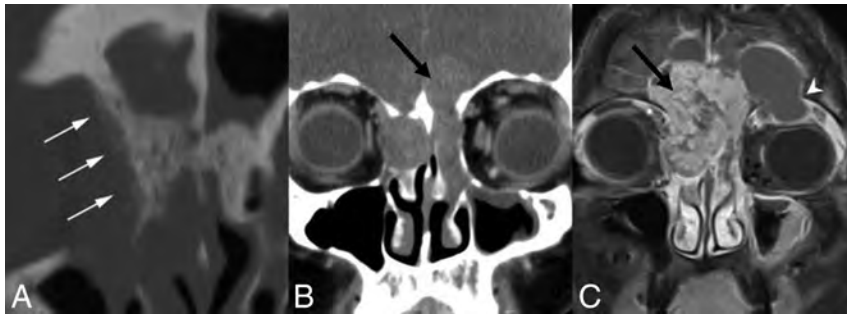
SMARCB1-deficient sinonasal carcinoma. A, Coronal noncontrast CT shows the “hair on end” pattern of calcification/periosteal reaction (*white arrows*) described in several published cases. Coronal postcontrast CT (B) and coronal T1 postcontrast, fat-saturated (C) MR images in a second patient demonstrate an enhancing nasoethmoid mass eroding the floor of the anterior cranial fossa (*black arrows*). There is also erosion of the right lamina papyracea with extraconal orbital extension. A secondary mucocele extends through the left orbital roof (*white arrowhead*).
